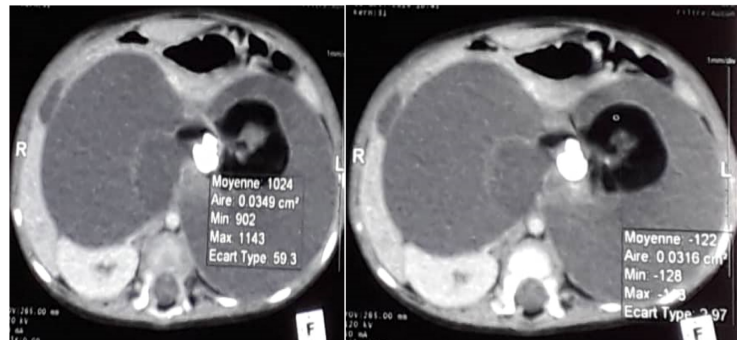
Abdominal CT in axial section showing the retroperitoneal teratoma with a compressive nature, with multiple components (cystic, tissue, fatty and calcium).
